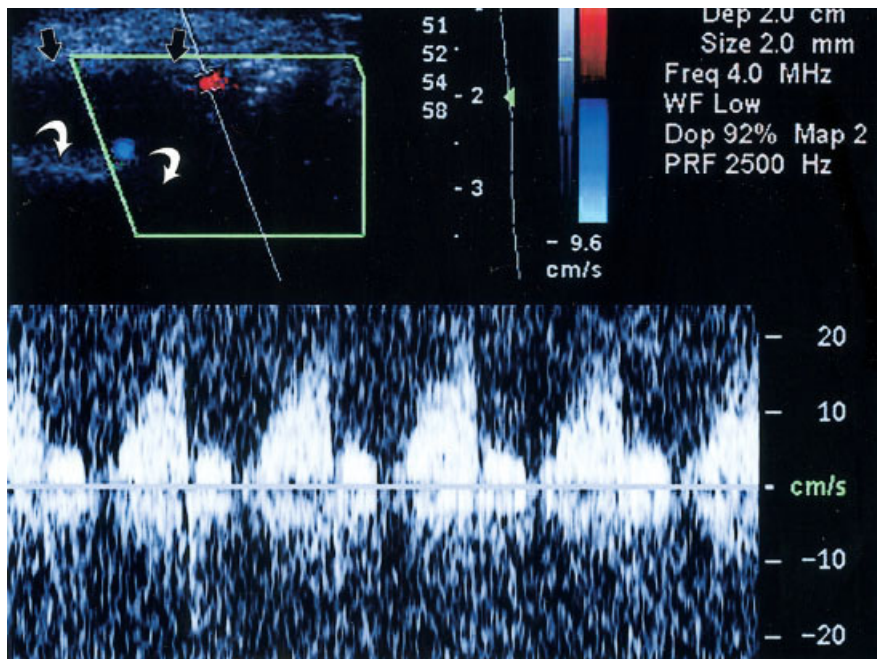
Duplex sonogram at the site of the fistula demonstrates the pulsatile pattern of flow from the fistula. Curved white arrows indicate the femoral cortex; black arrows delineate the knee joint capsule. Note the bidirectional flow at the site of the Doppler sampling window.
